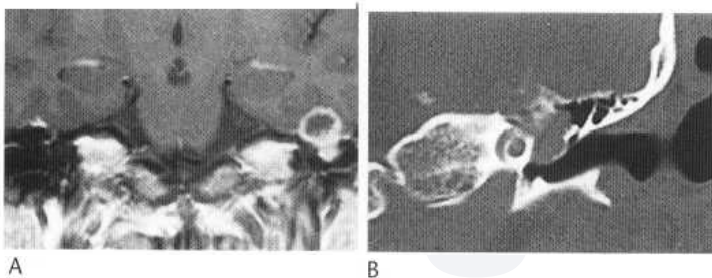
Coronal T_1 -weighted postcontrast image (A) showing a lobulated ring-enhancing mass in the region of the geniculate ganglion of the left facial nerve. The dedicated coronal CT (B) acquired on a bone algorithm shows associated bone destruction by the soft-tissue tumour with some involvement of the cochlea.
